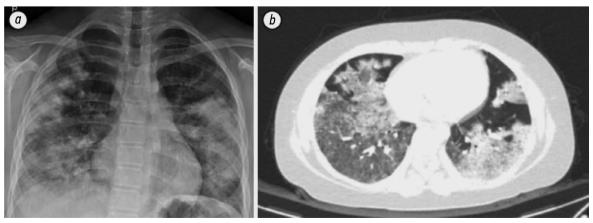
Radiography (a) and computed tomography (b) of the lungs of a 13-year-old female patient with Wilson's disease and anti-neutrophil cytoplasmic antibody-associated vasculitis: a — radiographic bilateral extensive focal consolidation; b — multifocal patchy ground-glass opacity corresponding to diffuse pulmonary hemorrhage [13]. © The Korean Academy of Medical Sciences, 2019.
